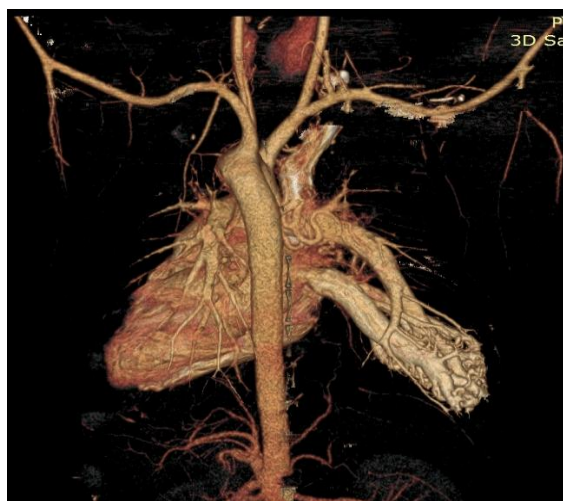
3D reconstruction image of Pulmonary CT Angiography showing A complex AVM.
